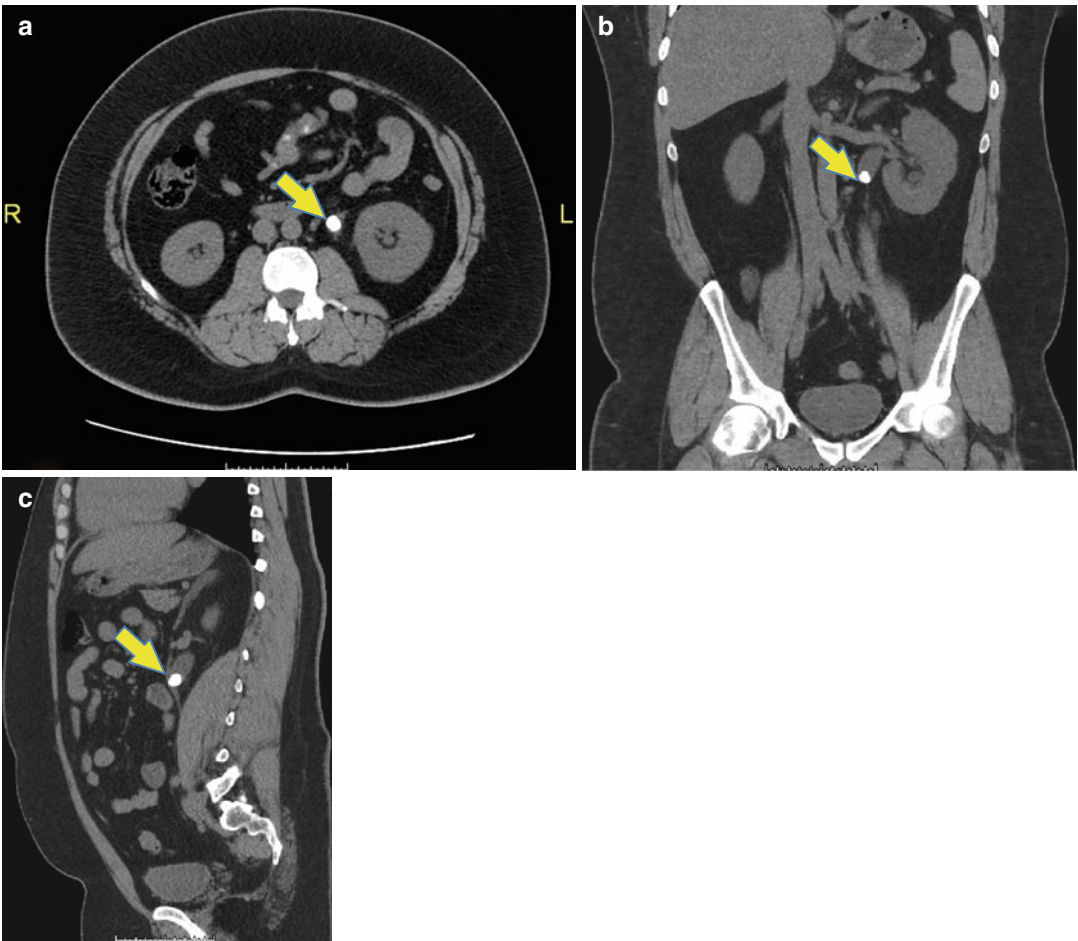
Multiple non-contrast renal protocol CT scan images of a patient with a ureteral stone in the proximal (*upper*) third of the left ureter (*yellow arrows*) in the (a) axial, (b) coronal and (c) sagittal views
